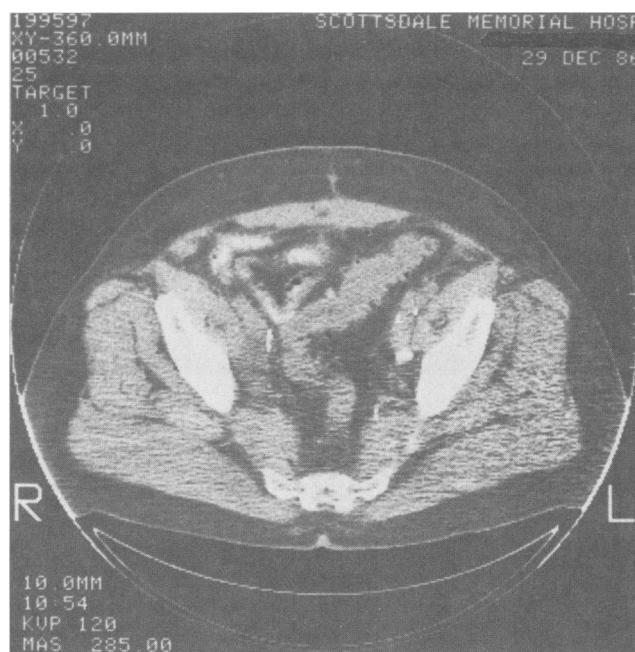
A follow-up CT scan shows complete resolution of the lymphocele.
